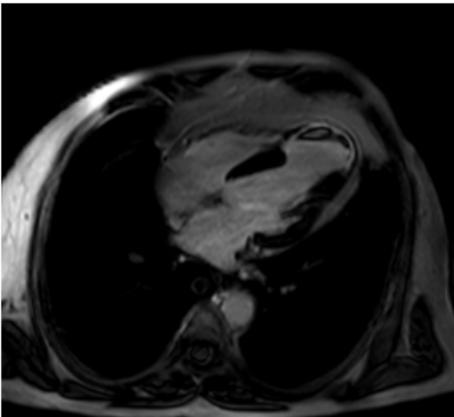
Cardiac MRI late gadolinium post contrast image demonstrates a subendocardial infarct with thrombus, seen as a filling defect (straight arrow).
